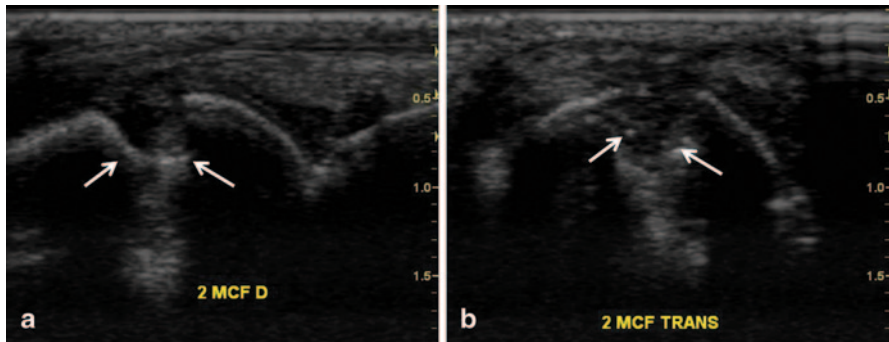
Ultrasound image of bone erosion in psoriatic arthritis. There is a discontinuation in the bone surface (cortical defect) which is visualized in a Longitudinal and b Transversal scans (*white arrows*)
